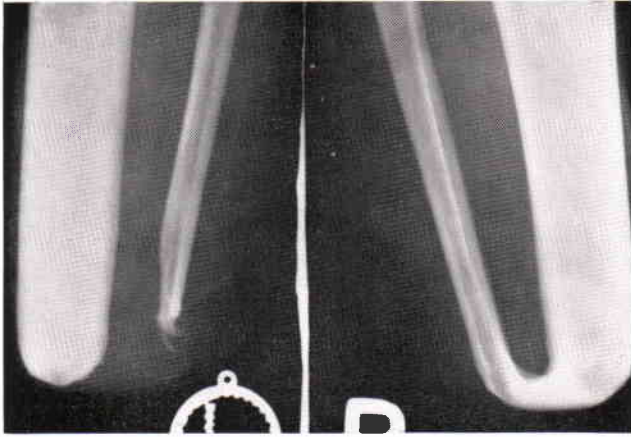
Case 3. Roentgenograms of bilateral amputee with osteoplastic revision of right stump only (taken 11 years after revision). Relative increase in thickness of cortex of fibula and tibia of right stump, with normal appearance of bone tissue, is remarkable.
